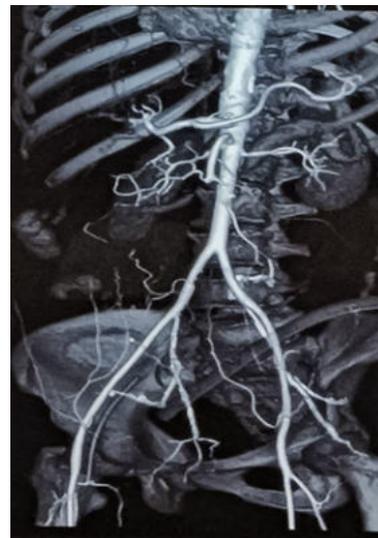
CT ANGIOGRAM showing complete thrombosis of SMA 5.5cm distal to its origin.
